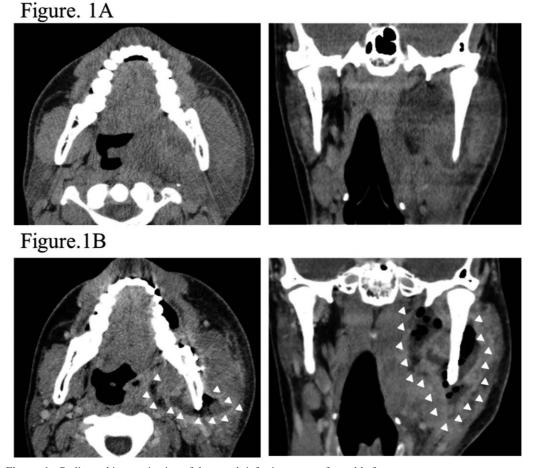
Radiographic examination of deep neck infection was performed before treatment. A, upper panel (Axial and coronal CT on the day of hospital admission. B, lower panel)Axial and coronal CECT on day 4. Formation of abscess with abnormal air collection in the supra-posterior area of the mandibular ramus and retropharyngeal space (white arrowhead).
